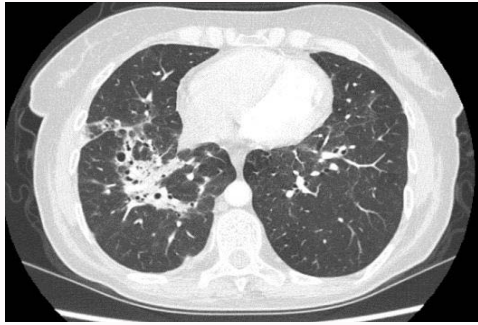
Thorax CT stage III sarcoidosis with parenchymal infiltrations, fibrotic and bronchiectasis lesions in the middle lobe with ground-glass opacities in both lungs.
